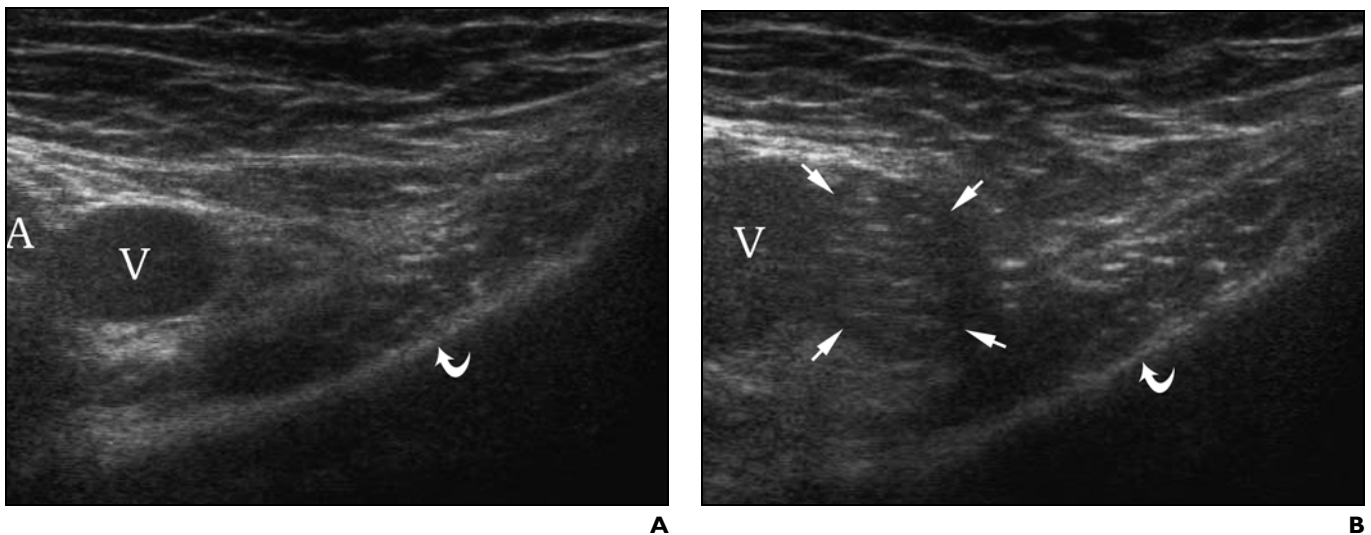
31-year-old woman with femoral hernia. Sonogram of right inguinal region parallel to and caudad to inguinal ligament corresponding to transducer position 4 in Figure 4.
